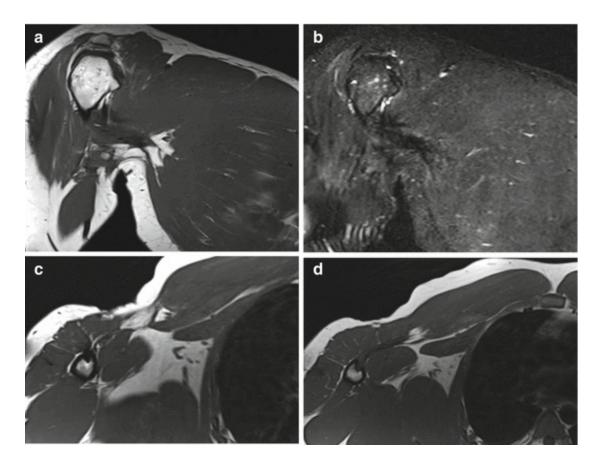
Postoperative follow-up of pectoralis tendon repair using the bone trough technique. Coronal T1-weighted (a) and fat-suppressed T2-weighted (b) as well as axial T1-weighted MRI (\mathbf{c}, \mathbf{d}) show fibroscar alterations at humeral insertion
